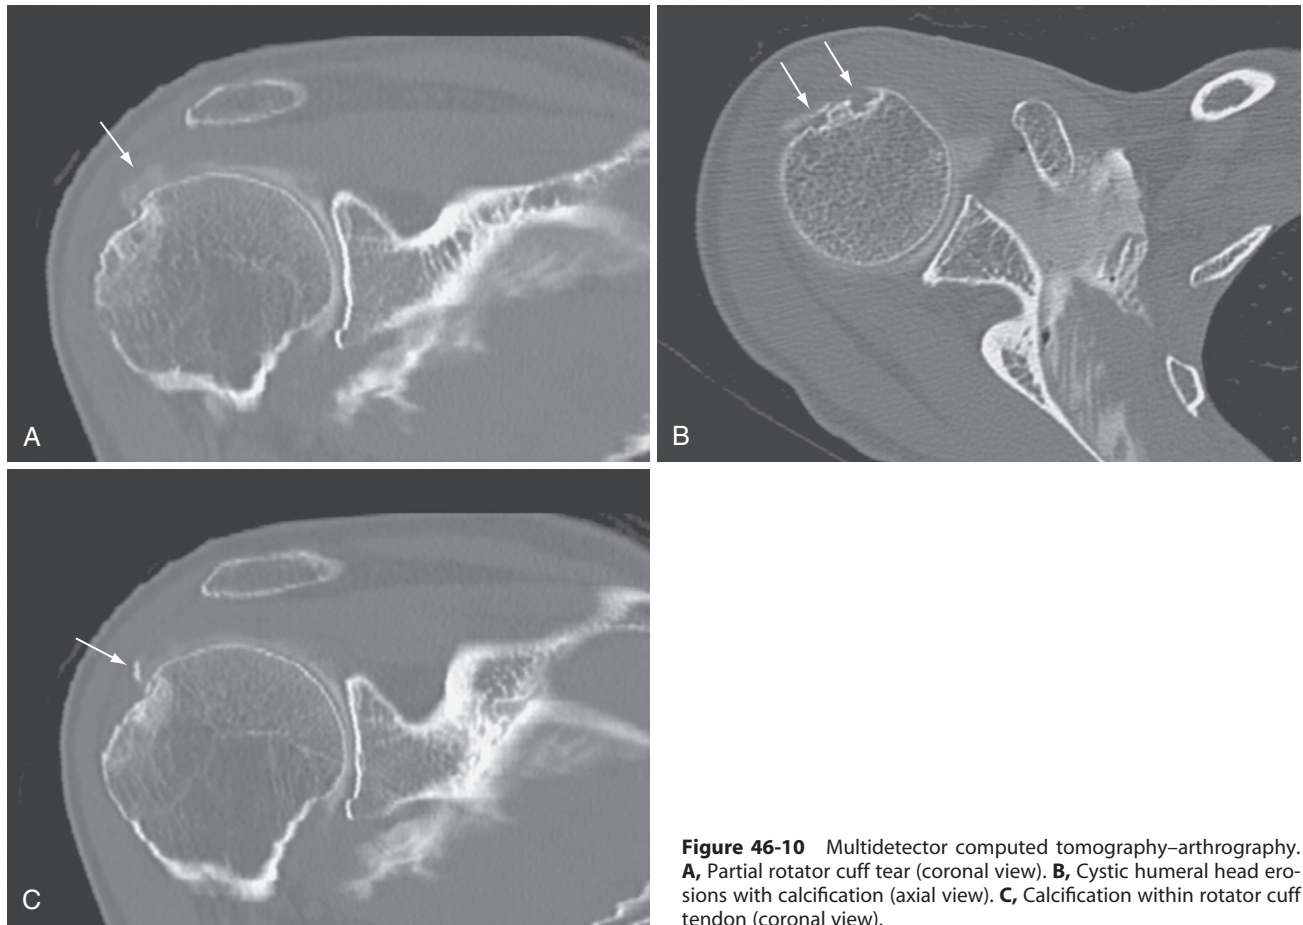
Multidetector computed tomography–arthrography. A, Partial rotator cuff tear (coronal view). B, Cystic humeral head erosions with calcification (axial view). C, Calcification within rotator cuff tendon (coronal view).
